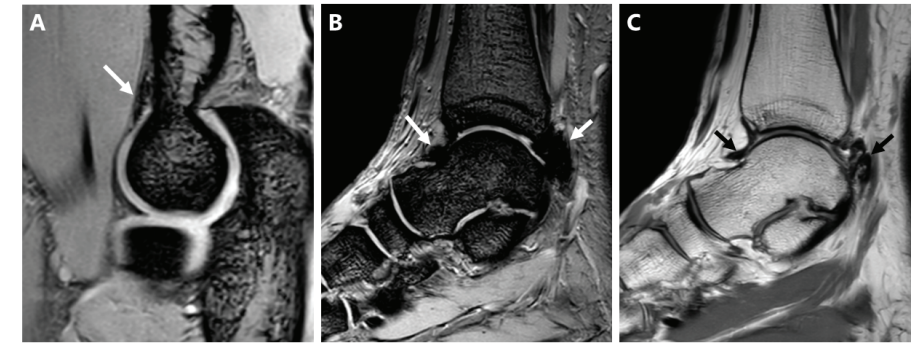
Examples of signs of previous subclinical bleeding on 3-Tesla magnetic resonance imaging scans of joints without a history of joint bleeding.
